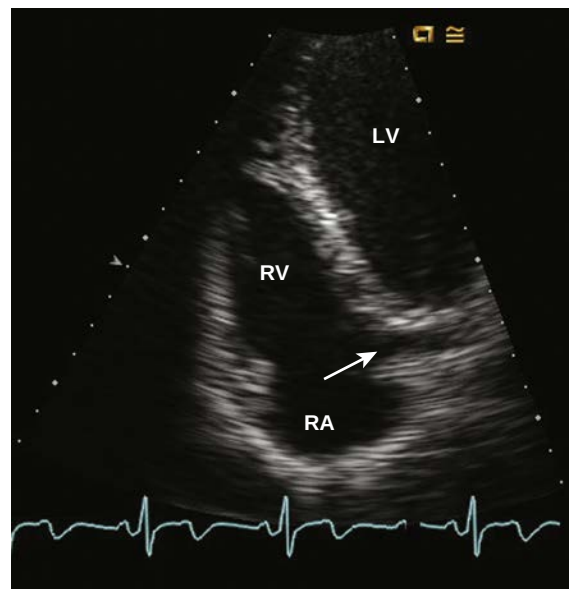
Coronary sinus. The entrance of the coronary sinus (arrow) into the RA is visualized by posterior angulation from the apical 4-chamber view.
